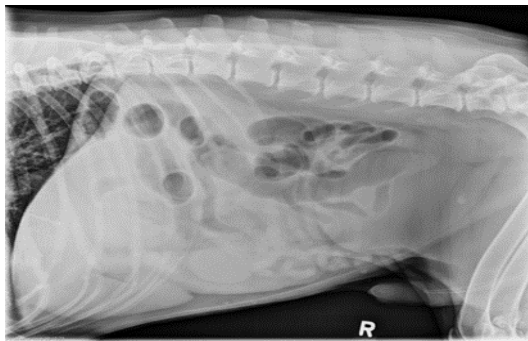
Left lateral abdominal radiograph showing splenomegaly, but does not confirm the presence of any splenic mass.
